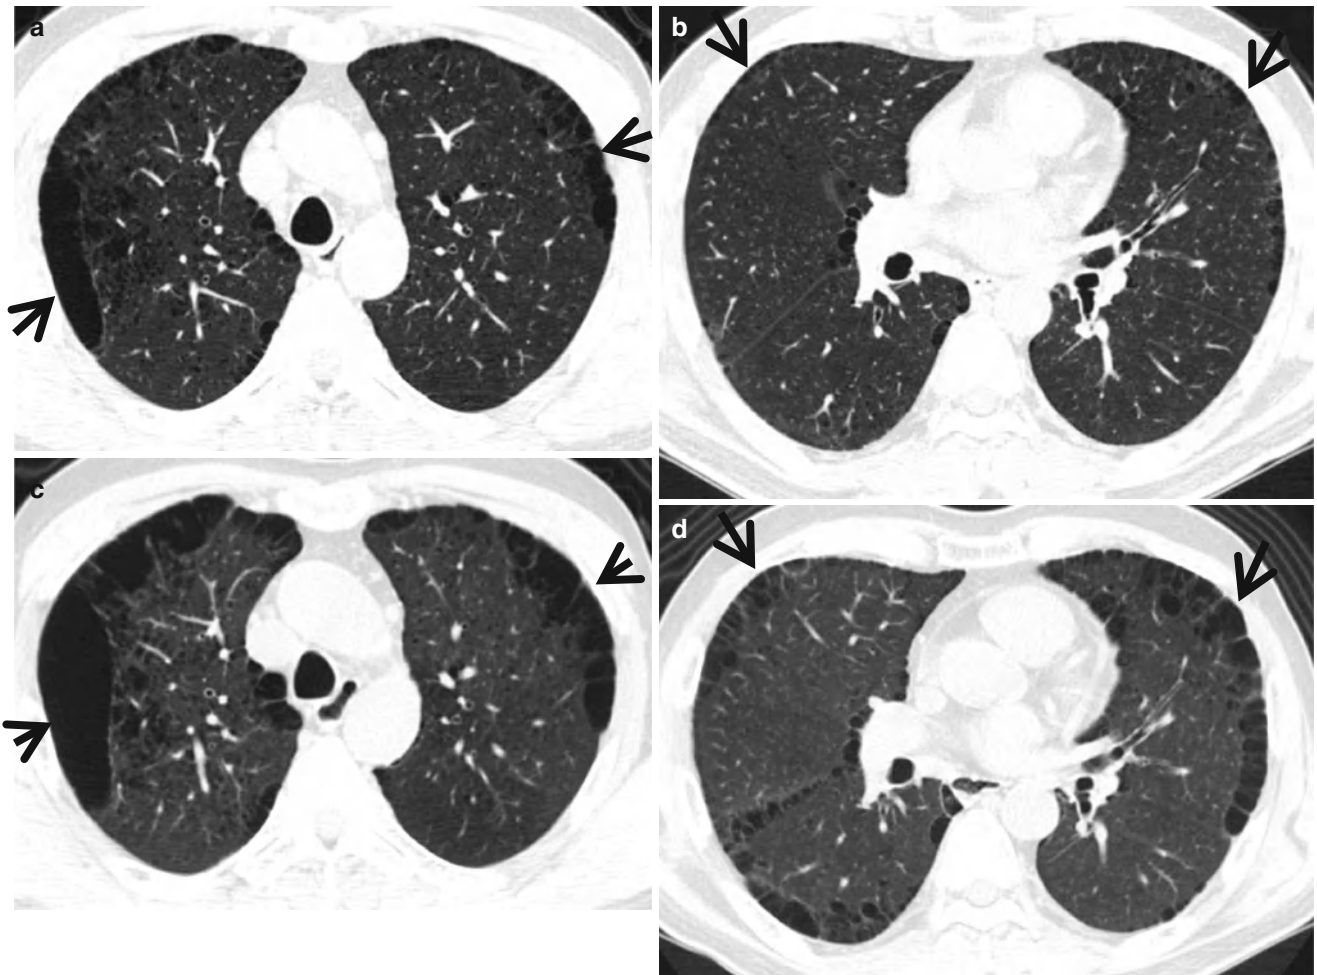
Paraseptal (distal acinar, bullous) emphysema showing evolution in a 50-year-old smoker man. (a, b) Lung window images of thin-section (1.0-mm section thickness) CT scans obtained at levels of aortic arch (a) and right bronchus intermedius (b), respectively, show
